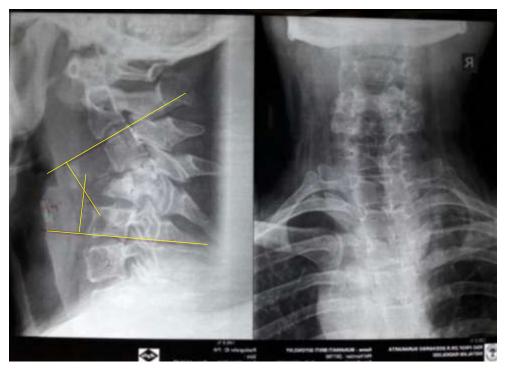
AP Lateral cervical X-Ray.
